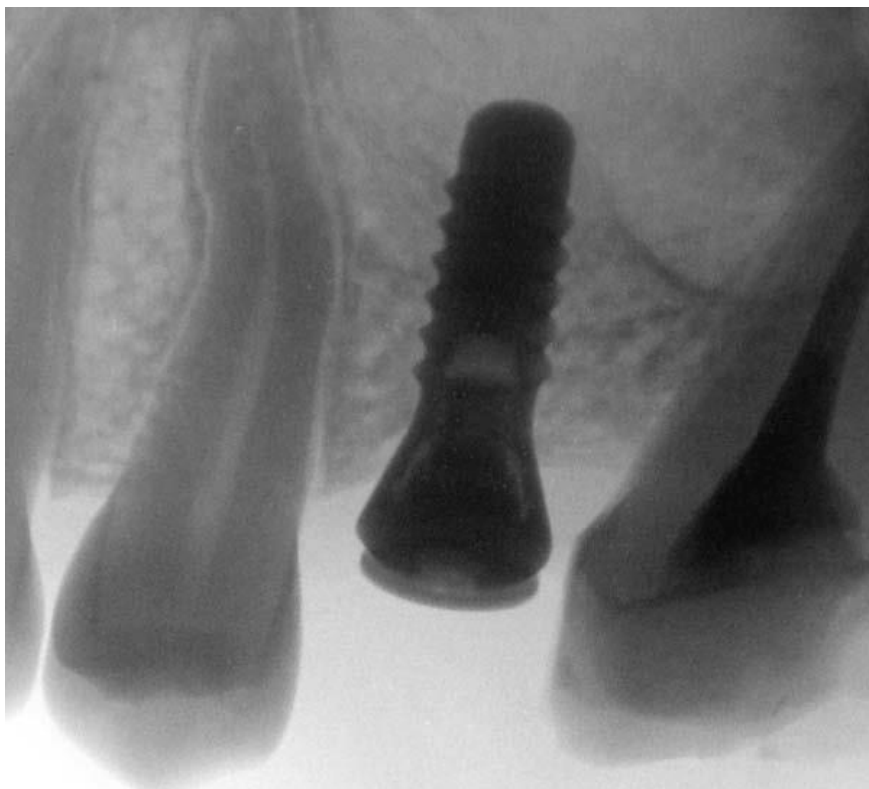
negative of X-ray (8 months) that shows the new bone trabeculae.*
